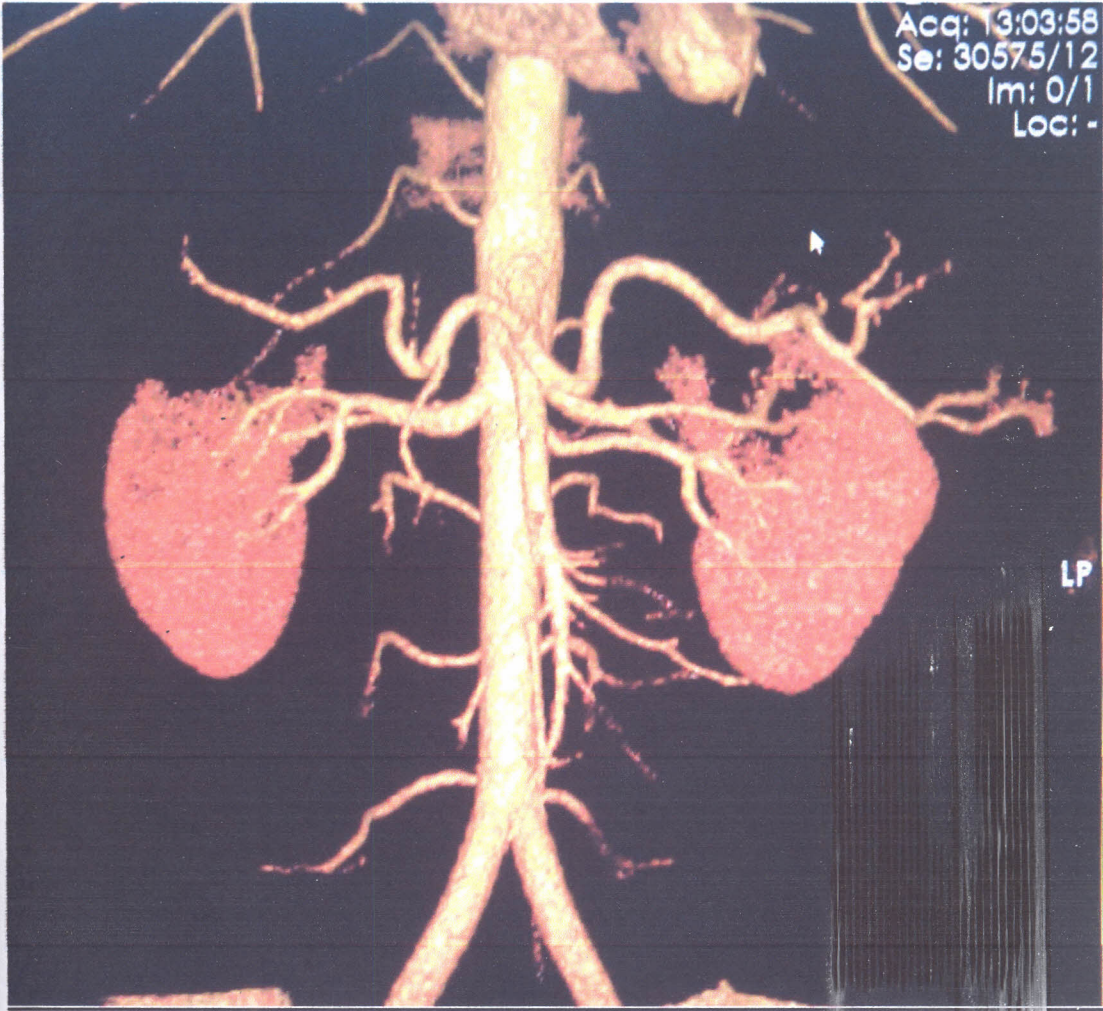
Volume rendering Renal CTA image of an adult man 34 years old potential donor (Fig4.6) with significant large accessory renal artery on the left.
